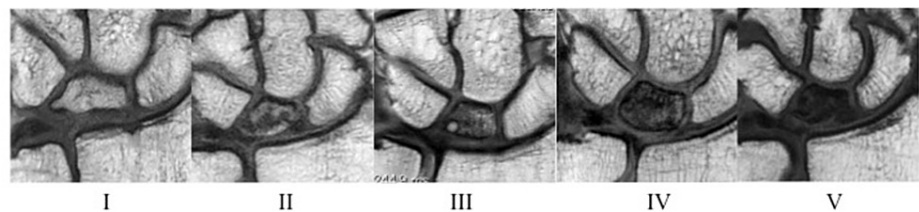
MRI grading system using the T1 or PDW coronal image
